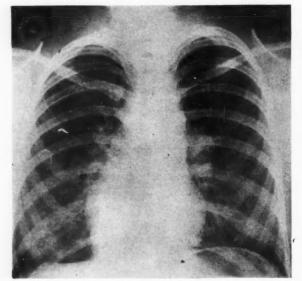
Roentgenogram in postero-anterior position; note globular heart with prominence to right of sternum. Both pulmonary arteries, particularly the left, appear abnormally dilated.
